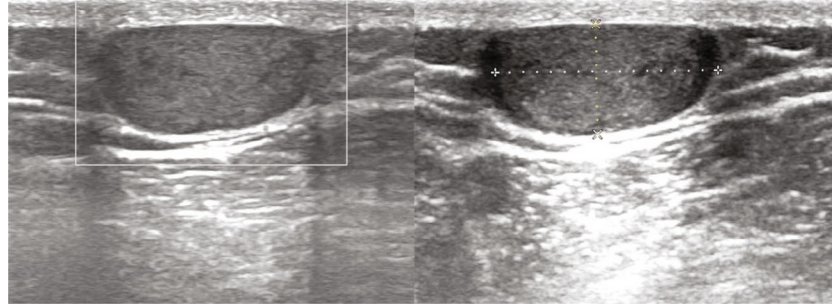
Sample ultrasound images of subcutaneous cyst.
